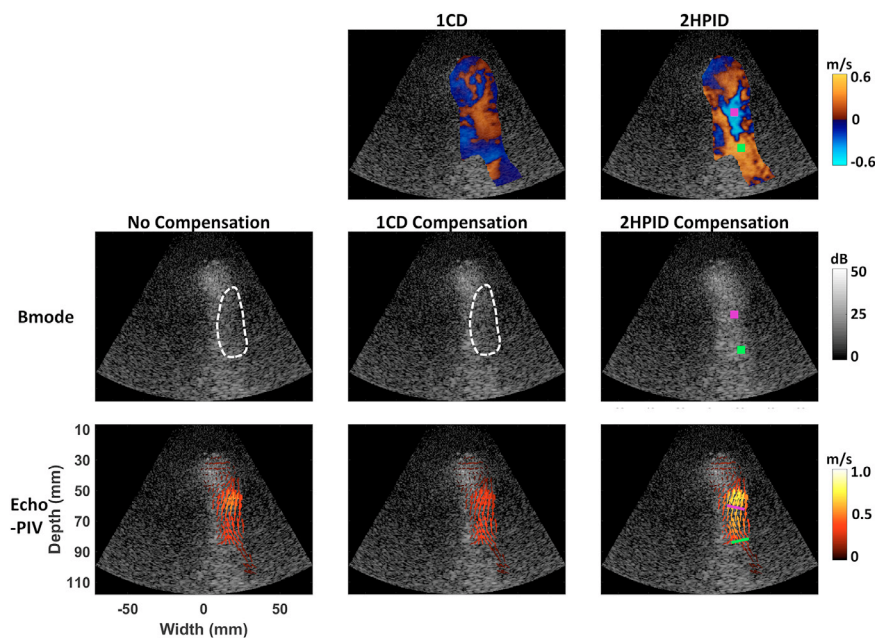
Example ventricular images in patient 2. Axial velocity images from 1CD and 2HPID (top). HFR CEUS B-mode images (center) and echoPIV images (bottom) before and after 1CD- and 2HPID-based compensation. The magenta (aliasing) and green (nonaliasing) boxes indicate the areas for B-mode intensities comparisons. Similarly, the magenta and green lines indicate the areas for vector velocities magnitude comparisons. White dashed windows indicate the decorrelation region. 1CD, fundamental-mode color Doppler; 2HPID, second-harmonic pulse inversion Doppler; CEUS, contrast-enhanced ultrasound; HFR, high-frame-rate.
